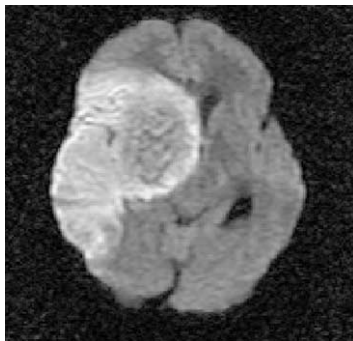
Diffusion-weighted MRI in a 15-year-old girl with acute lymphocytic leukemia receiving L-asparaginase, who suffered a devastating clinical stroke 10 hours before this scan. Cytotoxic edema is seen as bright signal within the right hemisphere.
